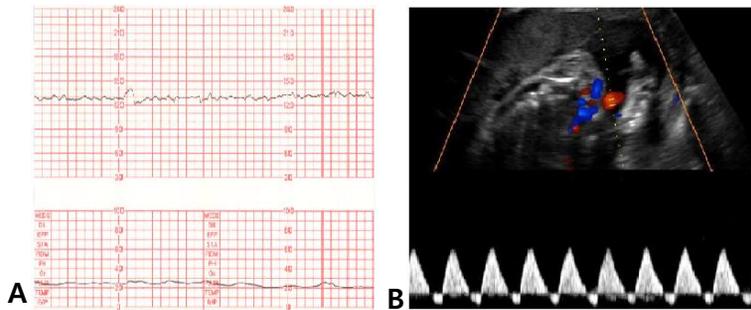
(A) Nonstress test result and (B) Doppler waveforms with reversed end-diastolic flow velocity in the umbilical artery six hours after the initial Doppler study.
